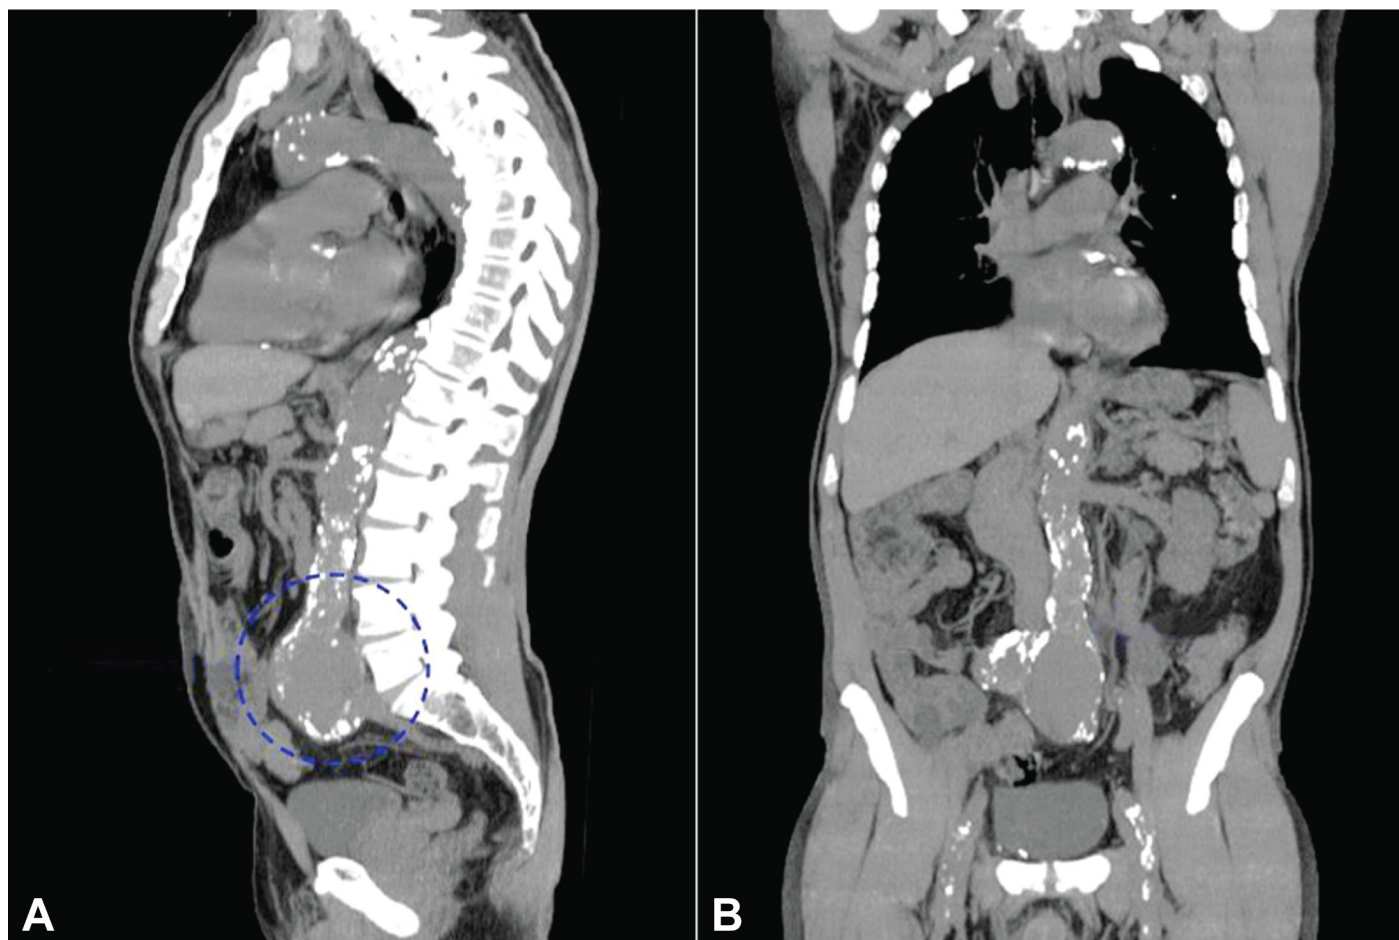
Computed tomography of the abdomen. A - Coronal plane; and B - sagittal plane, showing an aortic aneurysm at the site of the distal aorto-aortic anastomosis.
